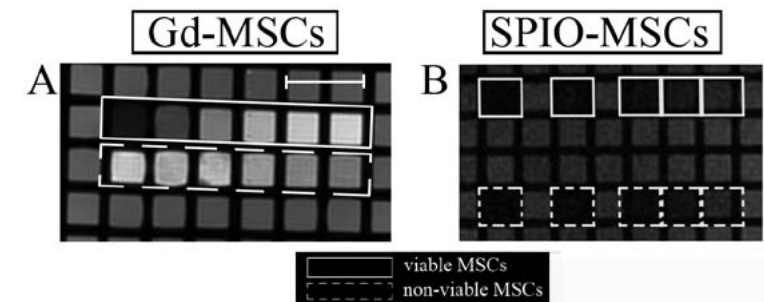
MR-imaging of in vitro dilution series of viable vs non-viable labeled MSCs at 3.0T. T1-weighted image of Gd-liposomes labeled MSCs (a) and T2-weighted image of SPIO-labeled MSCs (b). The viable cell serial dilution series is demarcated by the undashed rectangular box, non-viable cells by the dashed rectangular box. Cell concentrations from left to right: 1.65×10^5 , 8.3×10^4 , 4.1×10^4 , 2.1×10^4 , 1.0×10^4 and 5.1×10^3 MSCs μl^{-1} Ficoll. Scale bar represents 10 mm and applies to both (a) and (b).
